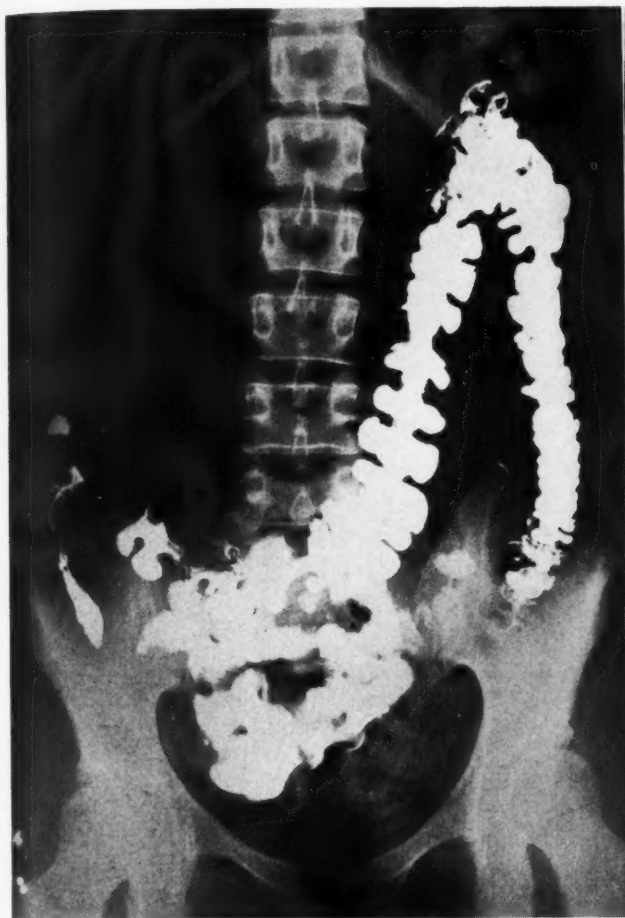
(a). Four-hour roentgenogram showing marked irritability of terminal ileum with rapid passage of the barium through this segment of the bowel. (This patient had previously had an appendectomy with relief of symptoms.)
